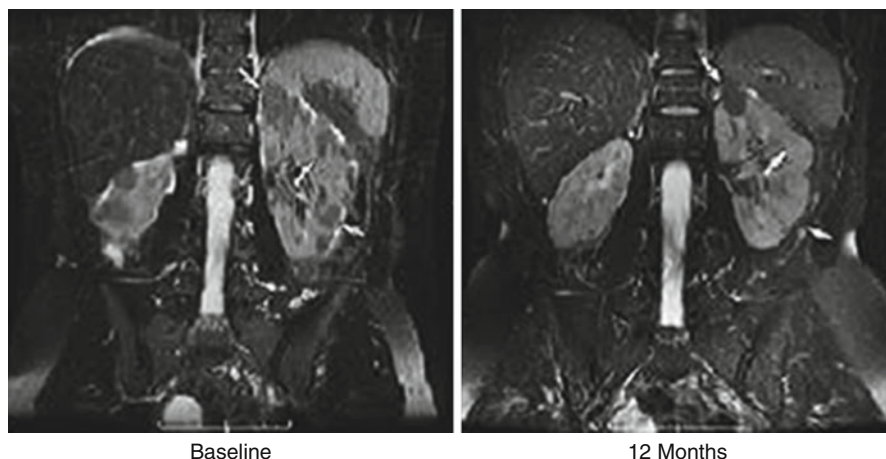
Phase 2 trial: Reduction in size of renal angiomyolipomas in a patient with TSC after 12 months of rapamycin therapy. (*Left*) Three lesions in the left kidney. (*Right*) At 12 months, the top lesion reduced in size and the bottom two lesions became imperceptible. Fast spin-echo T2-weighted MRI with fat suppression (Reprinted with permission from Bissler et al. [80])
